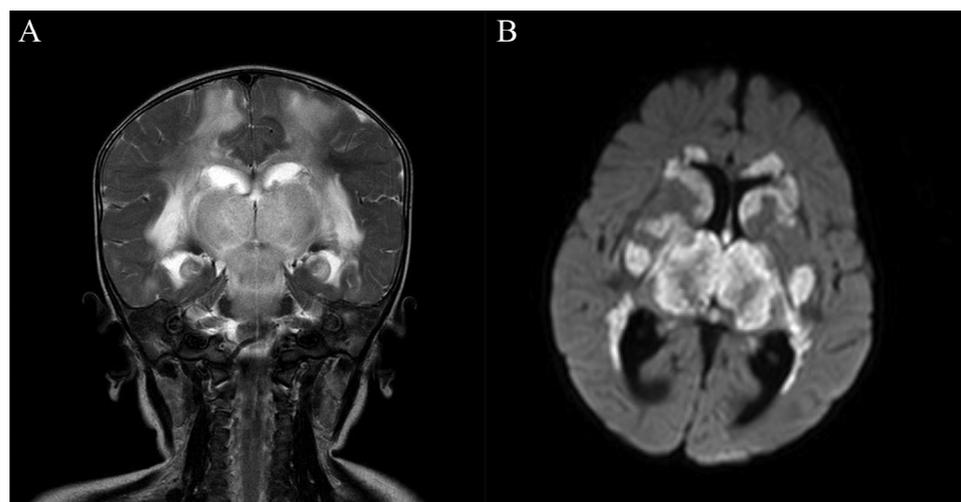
Magnetic resonance imaging from case 1 demonstrating typical features of acute necrotizing encephalopathy. A, Flair coronal image showing extensive, bilateral, symmetric enhancement of basal ganglia, midbrain, and periventricular areas. B, Extensive bilateral symmetric restricted diffusion of thalamic and periventricular areas.
